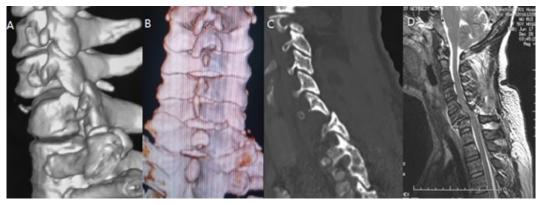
Preoperative three-dimensional computed tomography (CT) scan (A, B), and sagittal CT scan showing the locking of the C6-7 facet joint (C) with associated spinal cord compression confirmed on the sagittal T2-weighted magnetic resonance image (MRI) (D).
